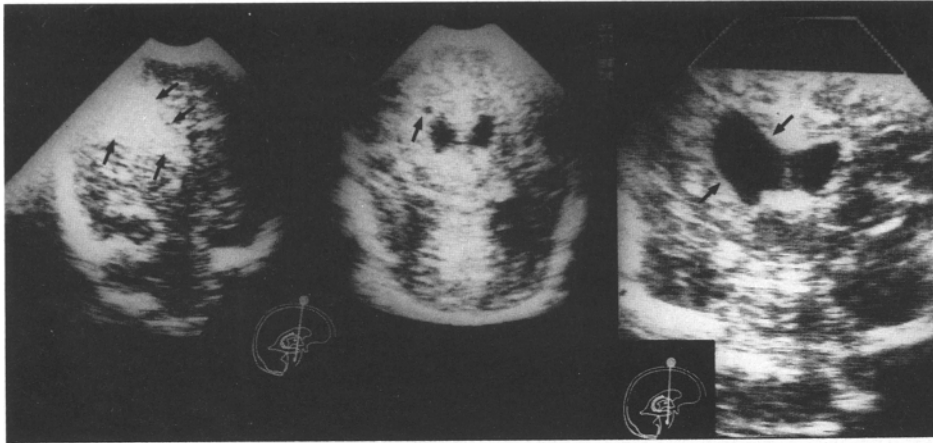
Patient 2. Ultrasound at the age of 5 weeks: left wedge-shaped area of increased echos with the apex at the foramen of Monro and the base near the left cortex. Three months: small cystic area of necrosis; 5 months: asymmetry of the slightly enlarged ventricles (*left to right*)
